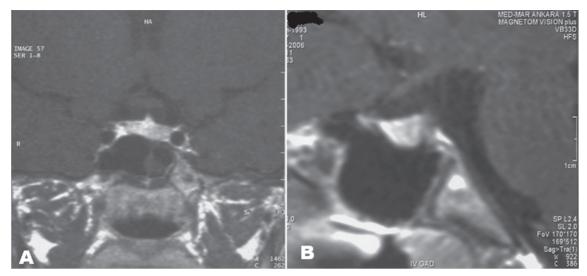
Repeat MRI after six months of levothyroxine treatment. T₁-weighted coronal (A) and midsagittal (B) images show resolution of the pituitary enlargement.
